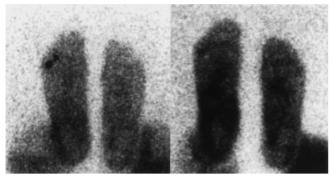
Thirty year old male patient with a recurrent soft tissue fistula of the left tibia after post-traumatic osteomyelitis. Delayed bone images (a) showed extensive uptake in the midshaft of the tibia, whereas ^{99m}Tc-HMPAO WBC scan (b) was mildly increased at the level of the old bone fracture. The SSEA-1 antibody was focally limited to the soft tissue at the site where the metal fixation had been stabilized previously. Both the WBC scan and the MAb scan were obtained at 4 h p.i. Limitation of the infection to the soft tissue was confirmed by fistula radiography. There was no contact with the underlying bone structure
